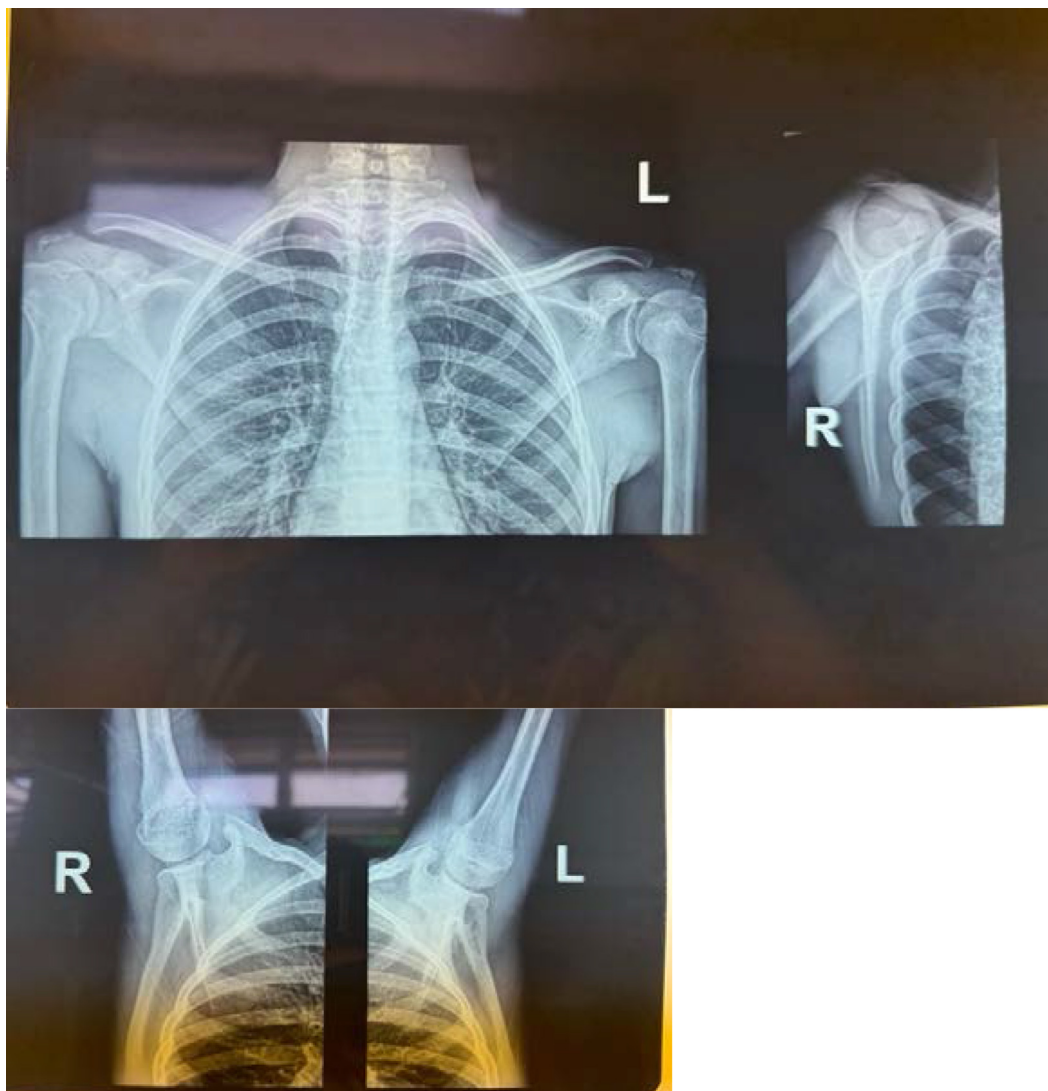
Postoperative X-ray images at 29 months of follow-up.
